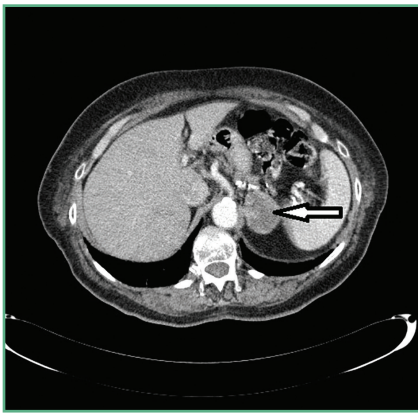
An axial slice of a contrast-enhanced CT scan of an adrenal carcinoma
